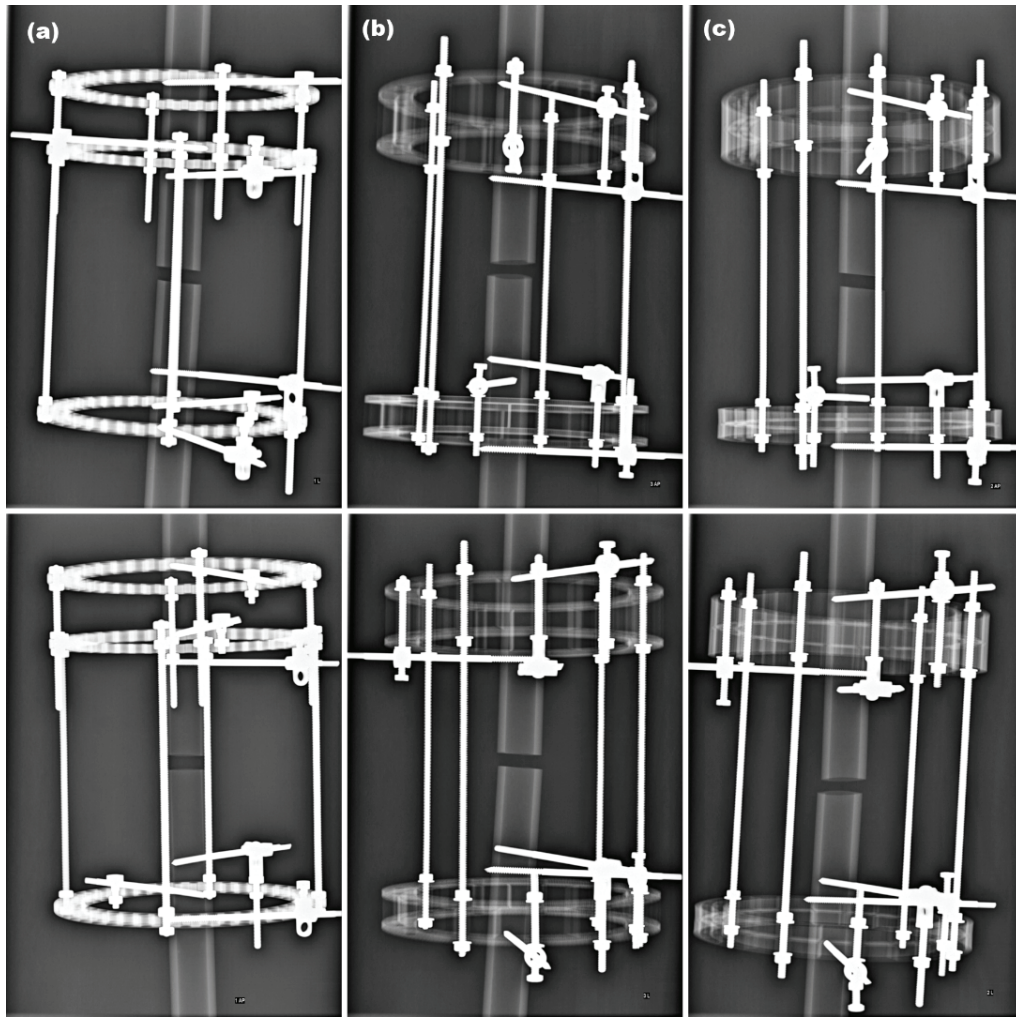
Radiographic images of the fixators in anteroposterior (AP, top) and mediolateral (ML, bottom) orientations: (a) aluminum rings, (b) I-type rings, (c) H-type rings
